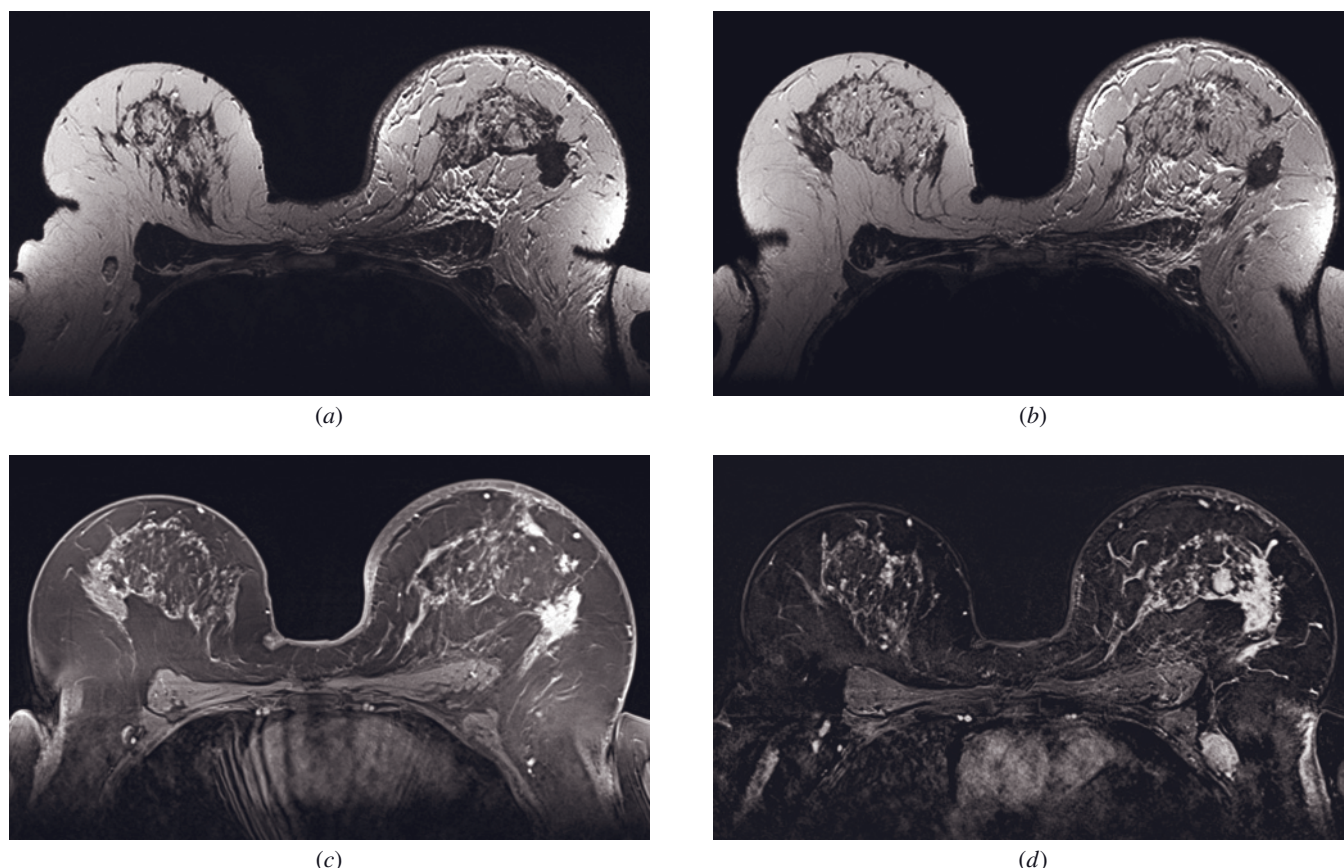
Inflammatory breast carcinoma (IBC). T2-weighted axial (*a, b*) and postcontrast GRE (*c*) and subtracted (*d*) axial images reveal left breast enlargement, diffuse skin thickening, abnormal nipple configuration, prominent vessels, and diffuse, cutaneous/subcutaneous, periareolar, pre- and subpectoral edema with an enlarged axillary lymph node. Multicentric tumors with spiculated margins are seen in the central and lateral aspect of the left breast, with washout kinetics.
